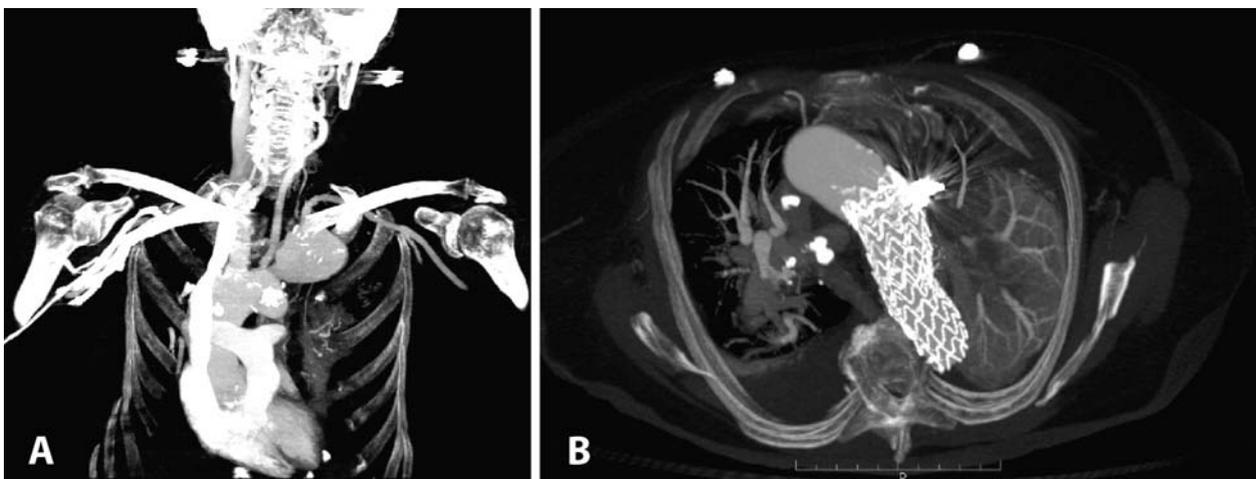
A) Short neck of subclavian artery aneurysm; B) Control computed tomography shows good position of the thoracic stent-graft covered origin of the subclavian artery and coils into the proximal part of the subclavian artery.
